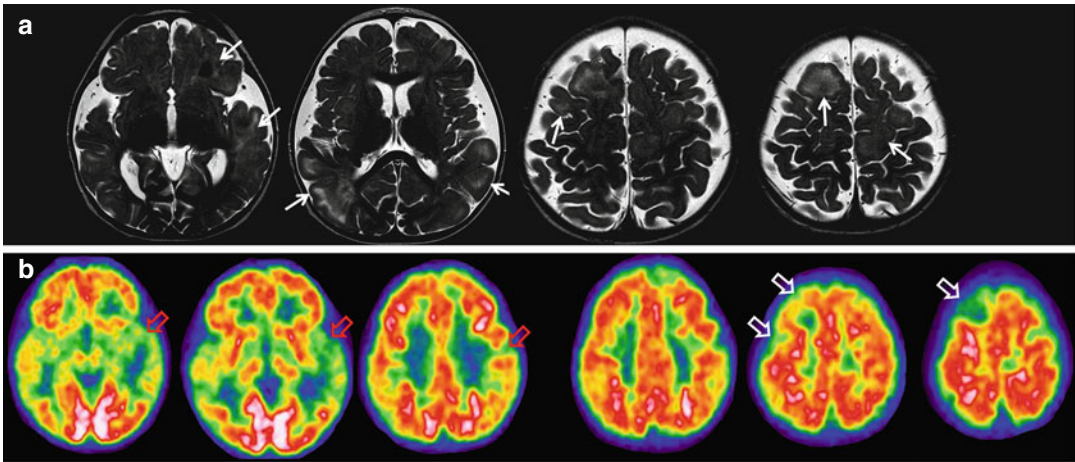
A 2-year-old boy with refractory epilepsy due to tuberous sclerosis, candidate to surgical treatment. (a) MRI (T2-weighted images) shows several cortical tubers (*thin arrows*). (b) The child was submitted to an interictal 18 F-FDG PET to recognize the epileptogenic tuber. All the tubers correspond to sites of hypometabolism on PET
